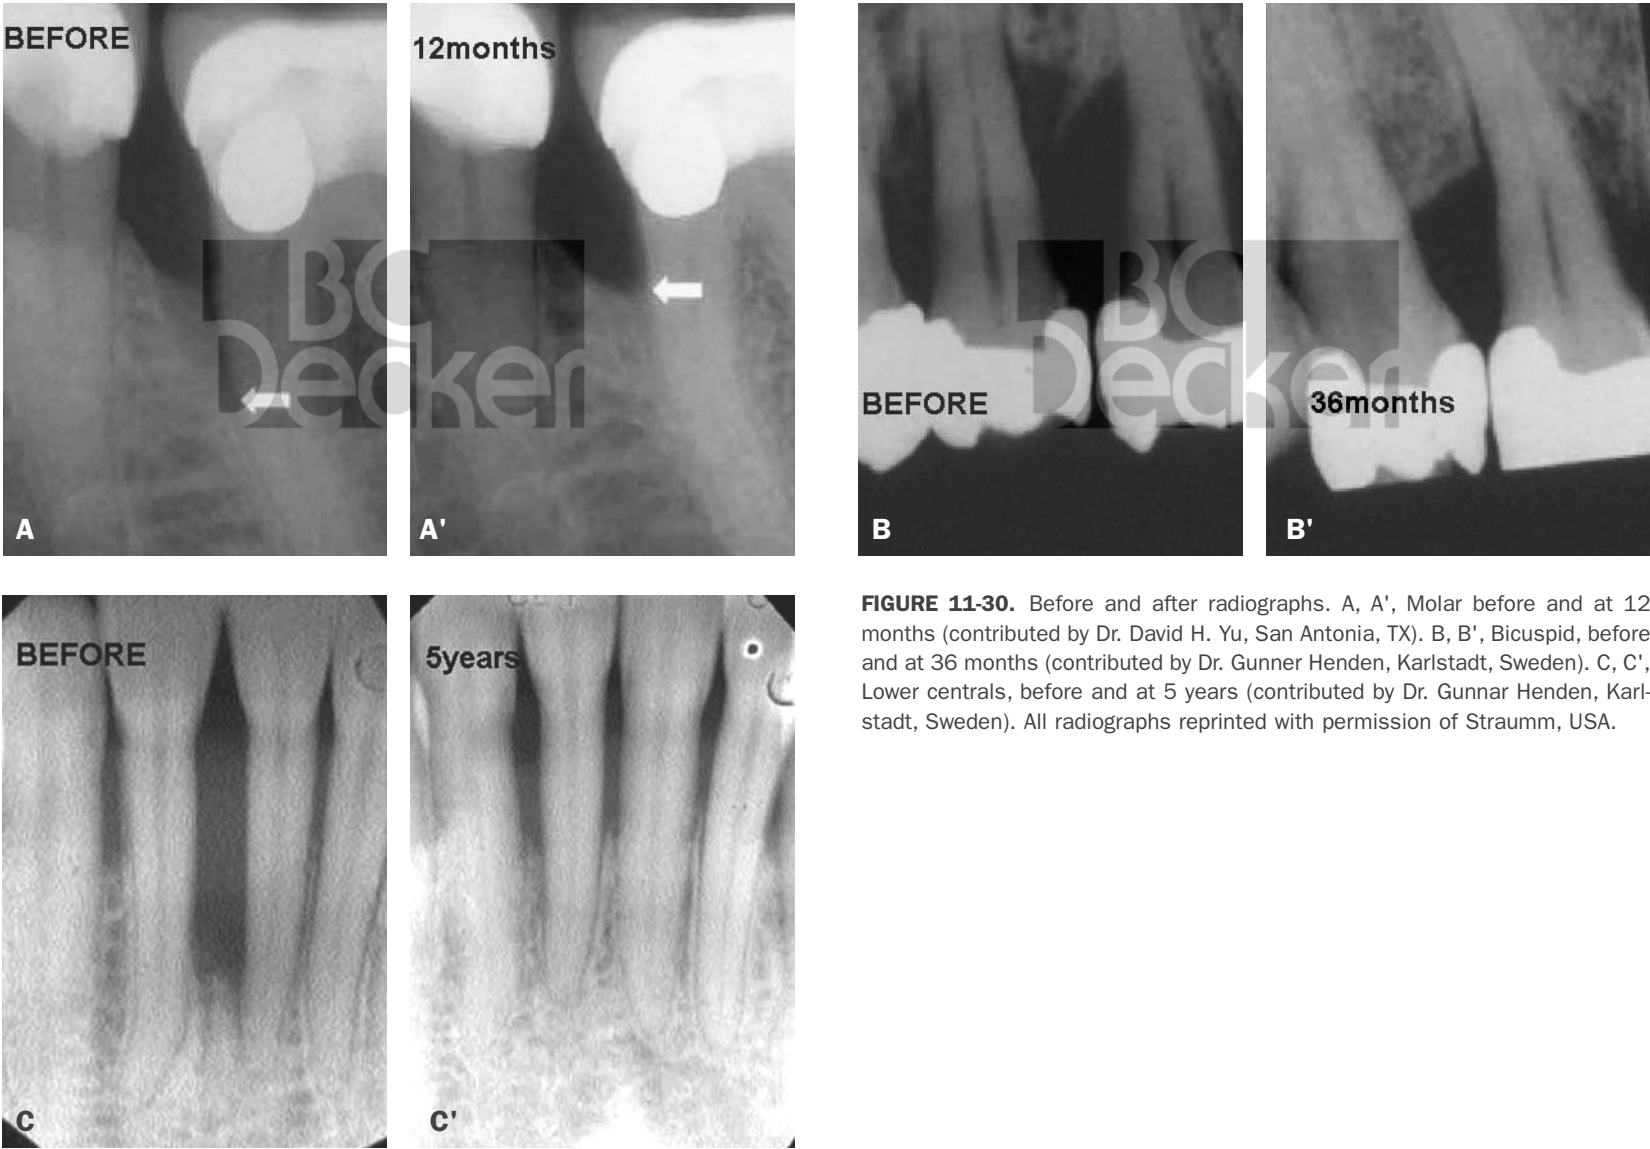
Before and after radiographs. A, A', Molar before and at 12 months (contributed by Dr. David H. Yu, San Antonio, TX). B, B', Bicuspid, before and at 36 months (contributed by Dr. Gunner Henden, Karlstadt, Sweden). C, C', Lower centrals, before and at 5 years (contributed by Dr. Gunnar Henden, Karlstadt, Sweden). All radiographs reprinted with permission of Straumann, USA.
